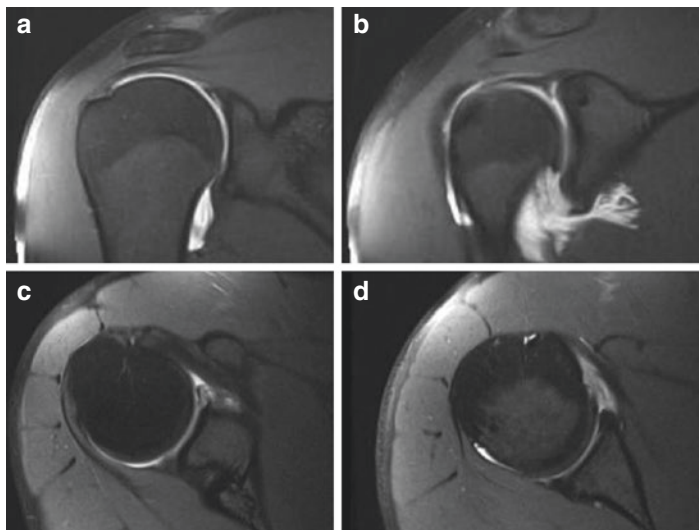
T2-weighted coronal image demonstrating a superior labral anterior posterior tear (a and b). Coronal images show the more anterior extent of this tear and the biceps remaining in the bicipital groove with concern for a HAGL lesion
